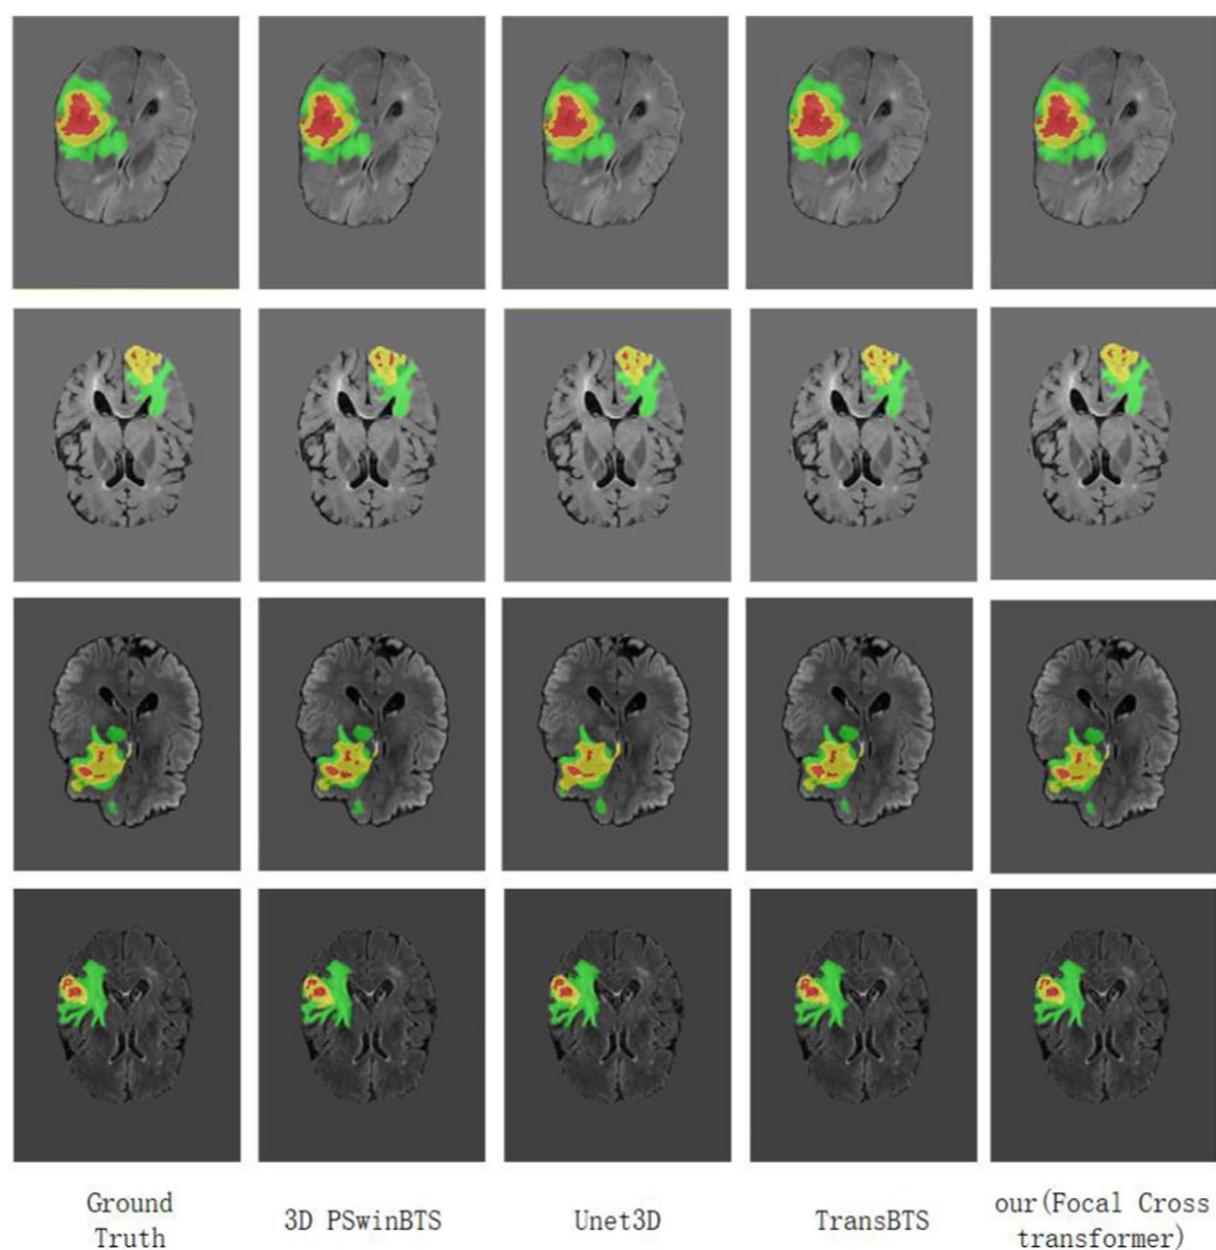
Visualization of MRI brain tumor segmentation under different methods. Focal Cross Transformer was compared with the results derived from Unet3D, 3D PSwinBTS, TransBTS, and other models on the BraTS 2021 dataset.
